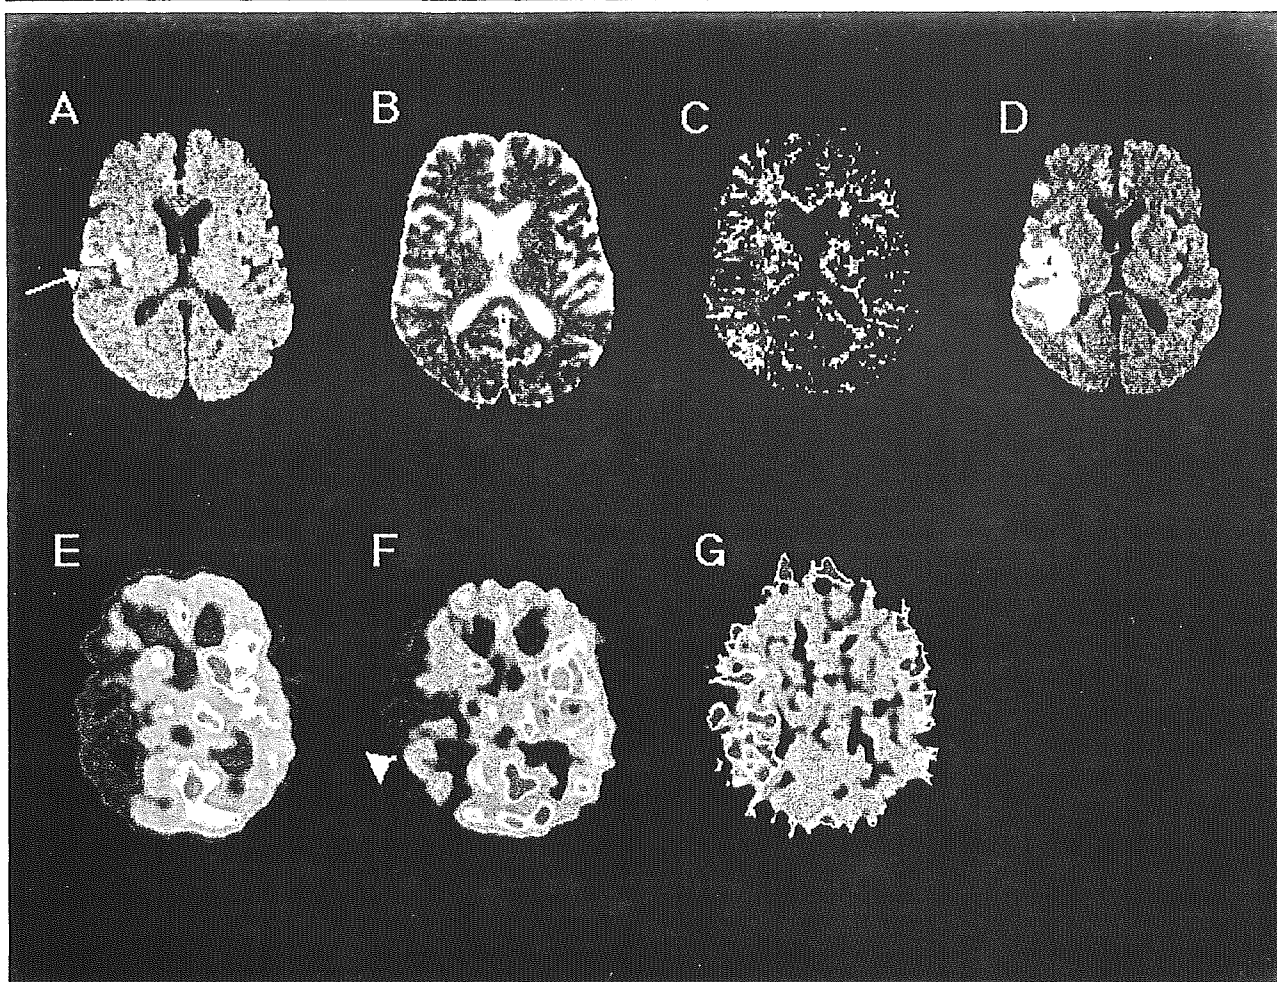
A 65-year-old woman with sudden onset of left hemiparesis and loss of consciousness. Cerebral angiography on admission revealed complete occlusion of right middle cerebral artery. (A) The initial DWI, (B) ADC image, (C) PWI obtained 80 minutes after onset demonstrated a small area with DWI abnormality (white arrow) and large perfusion-diffusion mismatch in right temporal lobe. (D) Follow-up DWI performed at day 3 showed enlargement of the DWI lesion, which was smaller than perfusion abnormality on initial PWI. PET images were performed 110 minutes after onset, and corresponding (E) relCBF image, (F) relCMRO<sub>2</sub> image, (G) relOEF image to initial MRI demonstrated moderate reduction of relCMRO<sub>2</sub> in the area of lesion volume expansion (white arrowhead), where diffusivity of water molecule was preserved on ADC image.
